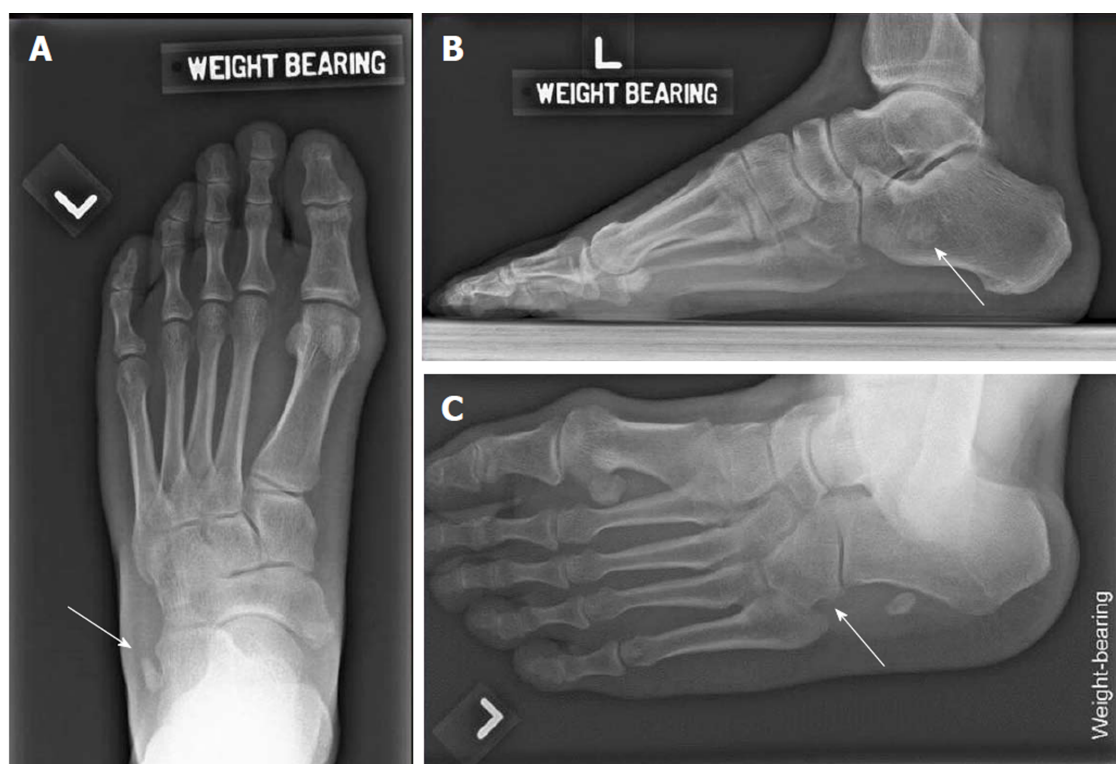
Initial weight bearing radiographs of the injured foot. A: Weight-bearing dorsoplantar view of left foot showing well-defined bony fragment (white arrow) lateral to the anterior left calcaneum; B: Left lateral weight-bearing views shows a bony fragment at the level of the calcaneum; C: Left oblique view. White arrow shows the absence of the os peroneum at its usual anatomical. Instead, it was displaced proximally to the level of the anterior calcaneum process.
